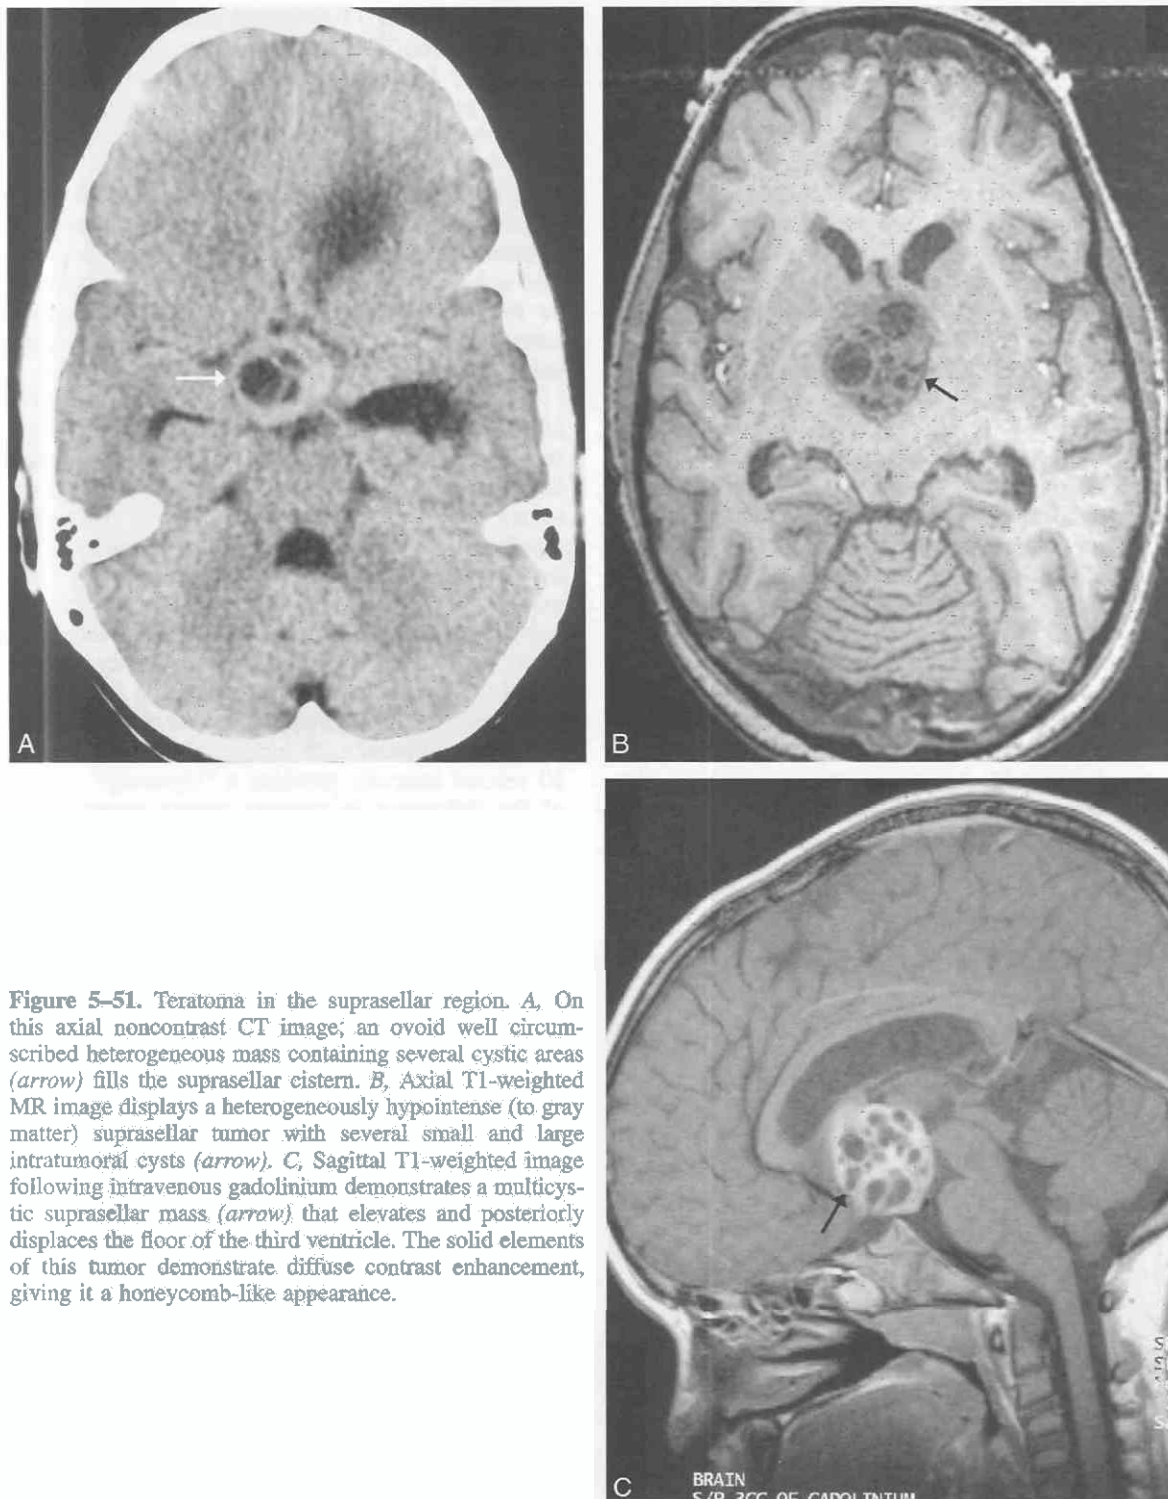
Teratoma in the suprasellar region. *A*, On this axial noncontrast CT image, an ovoid well circumscribed heterogeneous mass containing several cystic areas (arrow) fills the suprasellar cistern. *B*, Axial T1-weighted MR image displays a heterogeneously hypointense (to gray matter) suprasellar tumor with several small and large intratumoral cysts (arrow). *C*, Sagittal T1-weighted image following intravenous gadolinium demonstrates a multicystic suprasellar mass (arrow) that elevates and posteriorly displaces the floor of the third ventricle. The solid elements of this tumor demonstrate diffuse contrast enhancement, giving it a honeycomb-like appearance.
